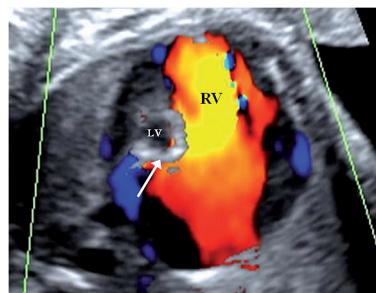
32 weeks of gestation. Hypoplastic left heart syndrome. RV — right ventricle, LV — left ventricle. Color Doppler Mapping
